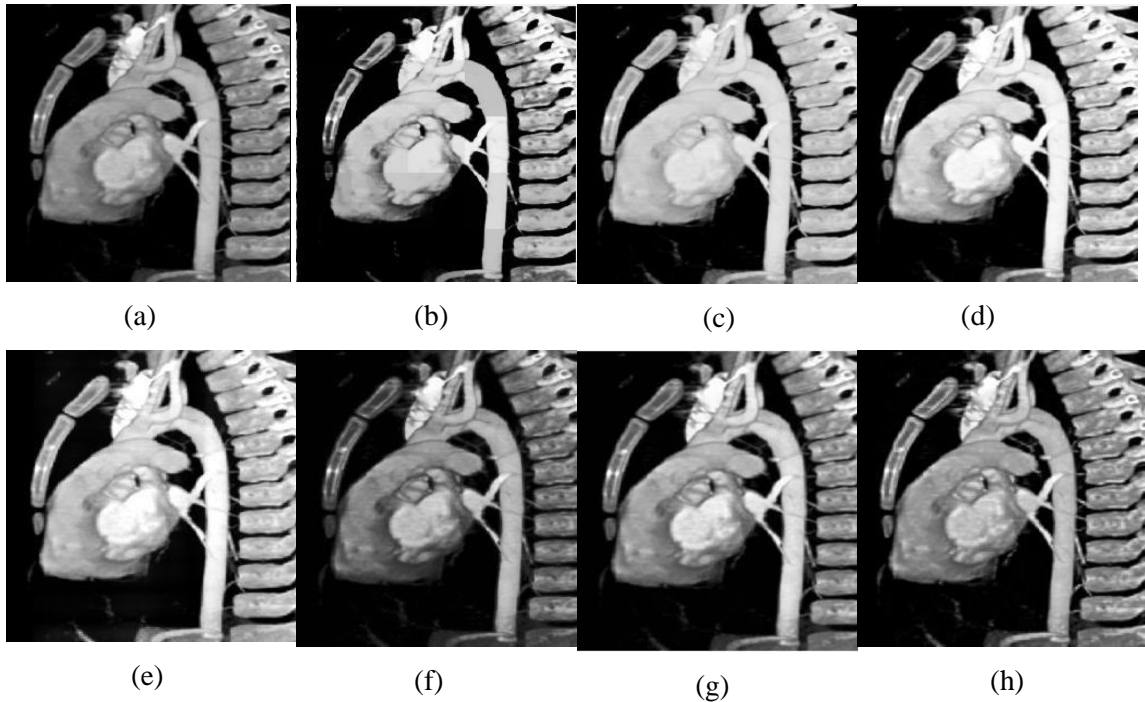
3.7 Input "CT-4" image and it's associated enhanced images (a) Input image, (b) S-curve, (c) AGC-DWT, (d) AGC-WHD, (e) GAGC-DWT, (f) EBCHE, (g) TCHE-DWT, (h) Proposed technique
